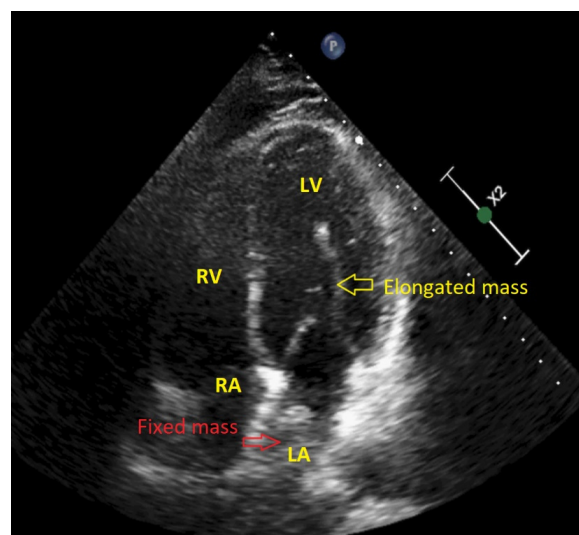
Apical 4 chamber view of trans thoracic echocardiography that revealed a large fixed mass in left atrium (red arrow) and also an elongated hypermobile mass that protrude from atrium to ventricle (yellow arrow)
